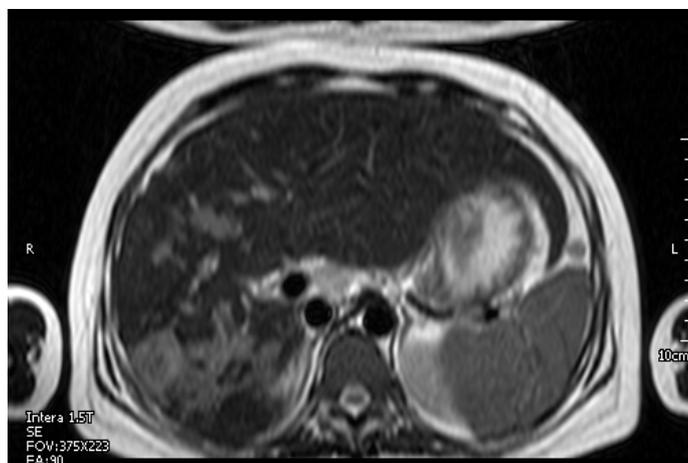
Liver MRI with hemorrhagic infarction of distal vessels of right lobe of the liver.
